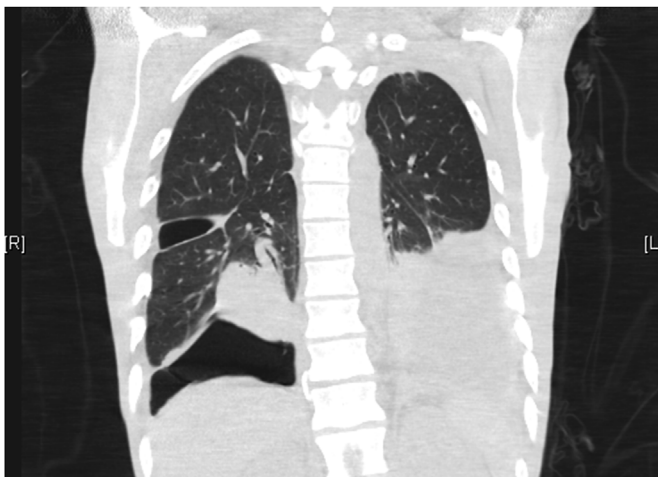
CT chest coronal.
